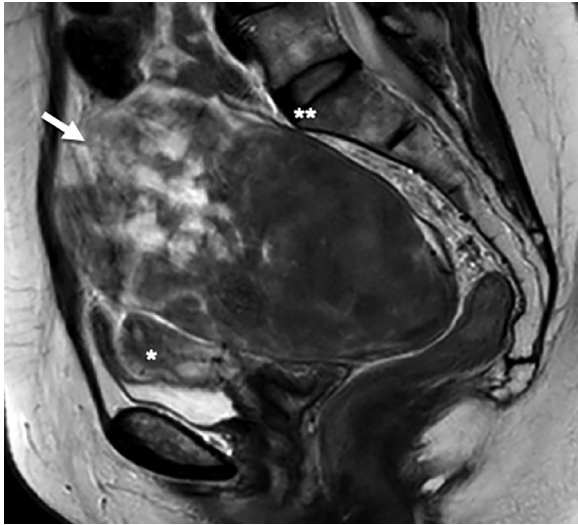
Sagittal T2-weighted image shows a well-defined solid mass (white arrow) posterior to the uterus (*), with posterior compression by the sacral promontory ().
